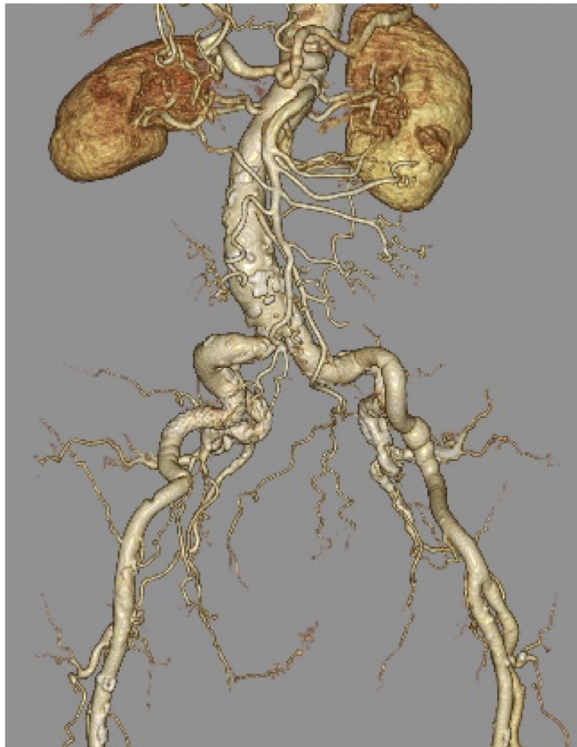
CT performed 3 weeks after admission revealed complete repair of ruptured iliac artery.
